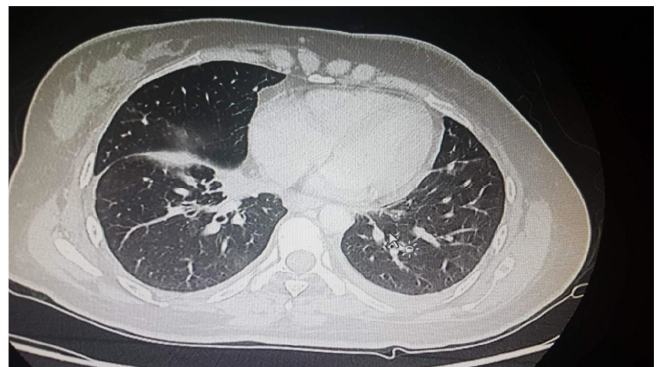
CT image showed pulmonary metastasis.
